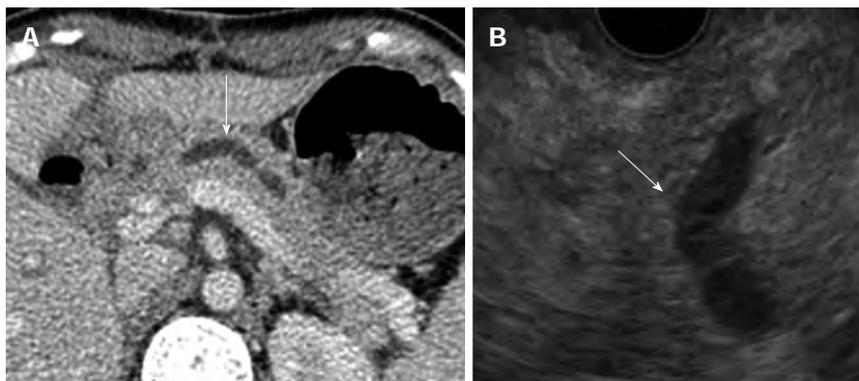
Computed tomography (A) and endoscopic ultrasonography (B) revealed a dilated pancreatic duct (white arrows).
